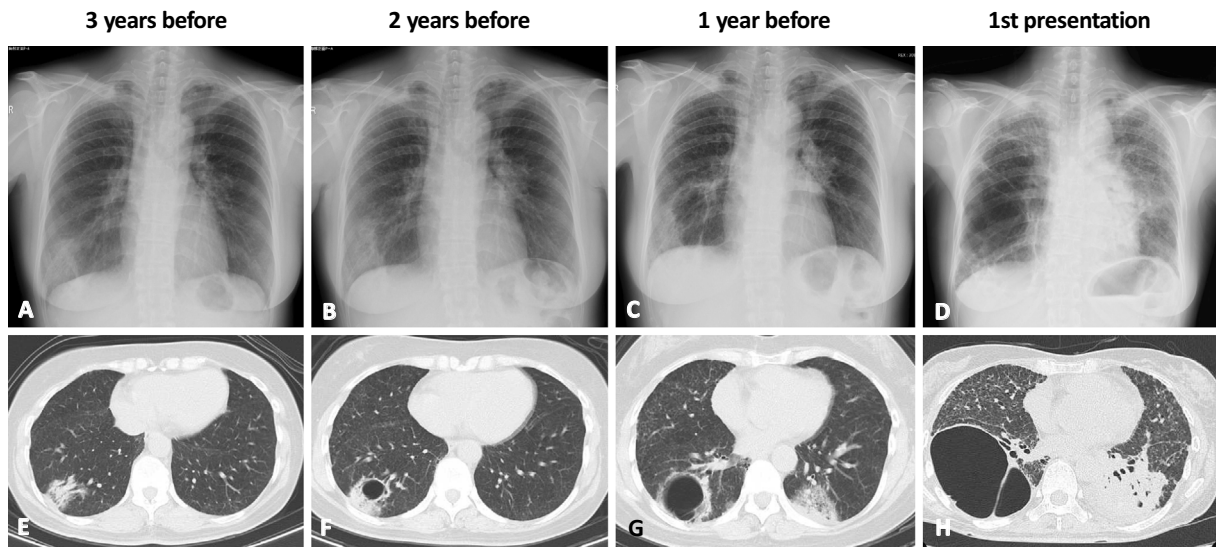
A chest radiograph taken three years prior to presentation shows dense infiltrate in the right lower lung fields (A), and consolidation with bronchial dilatation in the right lower lobes (E) was confirmed on thoracic computed tomography (CT). One year later, the consolidation progressed (B), and a 2-cm cystic lesion had appeared (F). Chest radiography and thoracic CT obtained 1 year prior to visiting our hospital showed expansion of the cyst to 4 cm in size (C, G). Chest radiograph taken on the first visit to our hospital demonstrated a 7-cm cyst in the right hemithorax (D) that was found to occupy the right lower lung lobe on thoracic CT (H).
